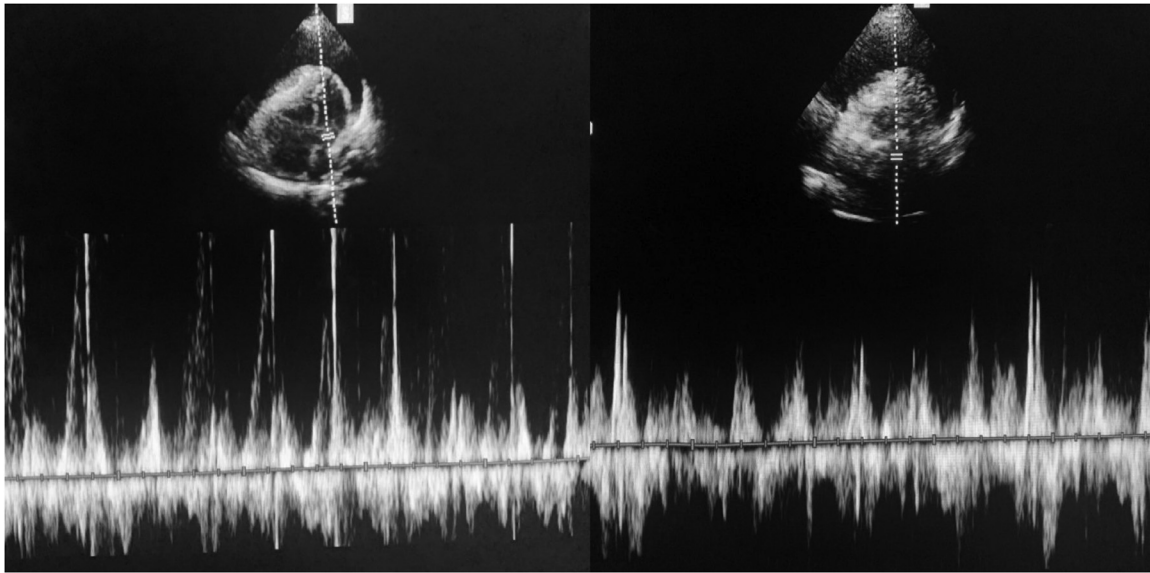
Transthoracic echocardiography showing significant respiratory variation in mitral and aortic valve velocities.
